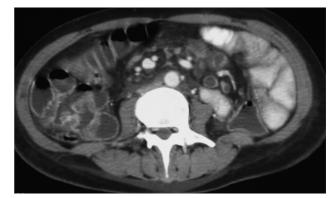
Abdominal CT revealed lymphadenopathy with cavitation and ascites
